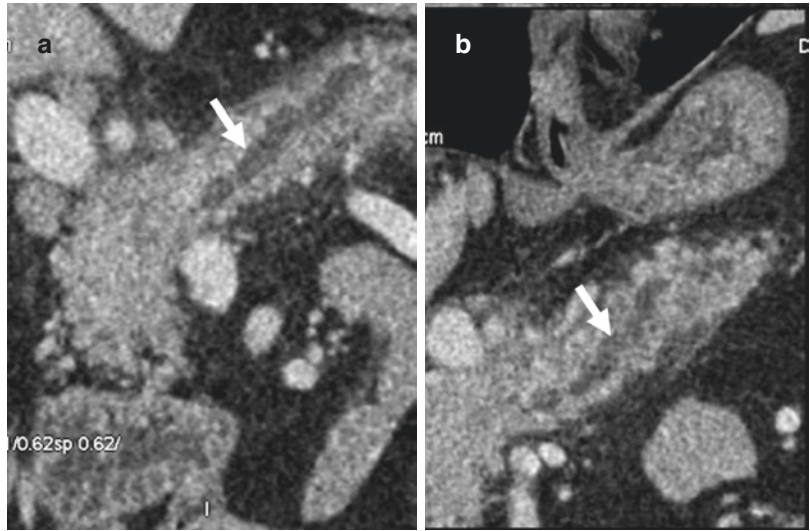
Improved detection of pancreatic cancer with dual-energy CT. (a, b) Standard contrast-enhanced image (a) shows vague hypodensity within the pancreatic head (white arrow). Iodine image (b) clearly shows a small
